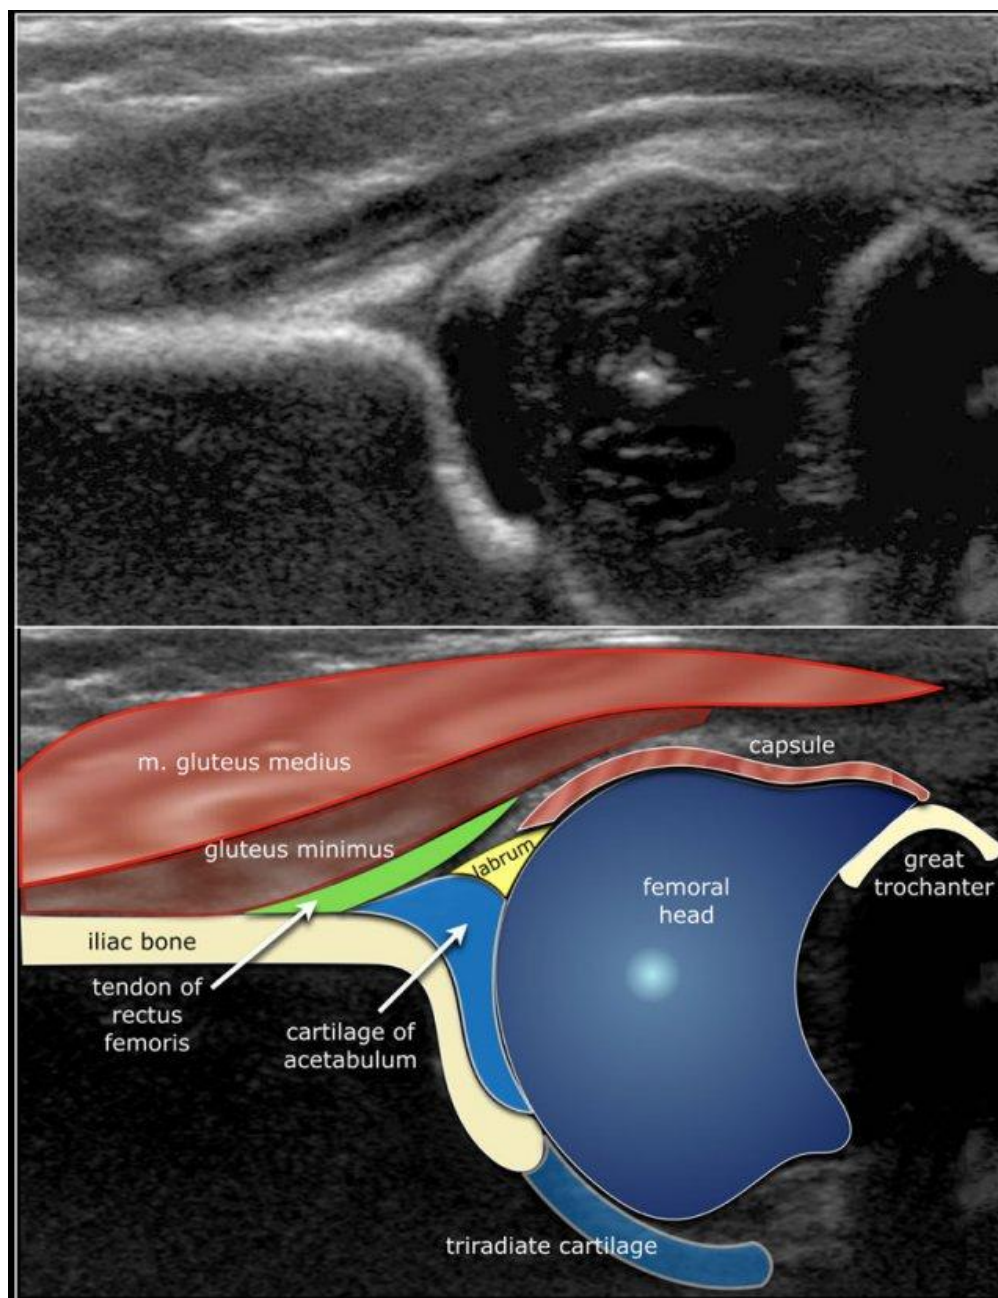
Ultrasound markers for determining the angles α and β (middle gluteus muscle, small gluteus muscle, joint capsule, large condyle, femoral head, acetabulum, acetabular cartilage, tricuspid cartilage, tendon of the thigh-lifting muscle, ilium)
